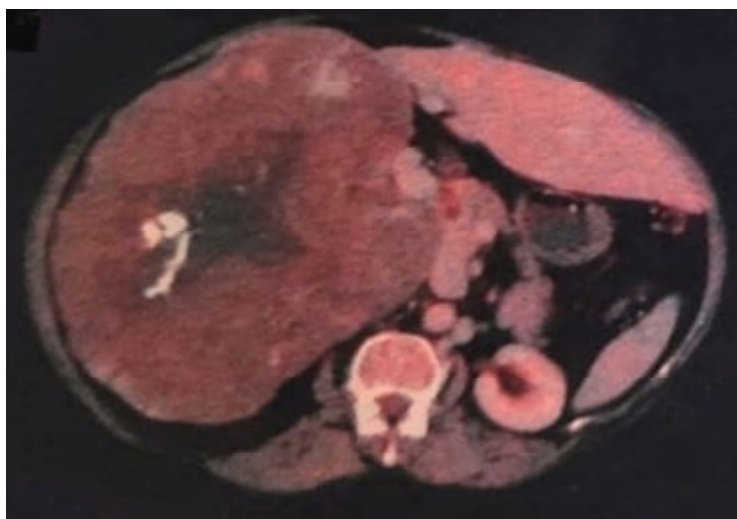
Non-FDG avid ill-defined enlarged nodular irregular hypo dense mass lesion entirely occupying right lobe with central scarring and calcification, SUV max 2.8 g/ml.
